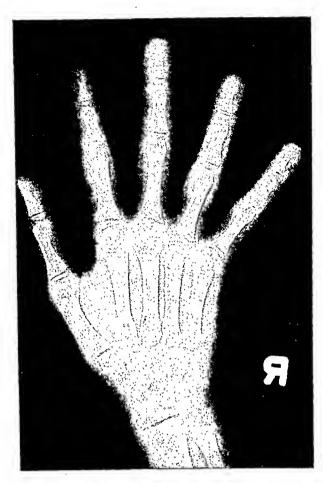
Case 1. Roentgenogram of the right hand. There is demineralization of all the bones with elongation of the metacarpal bones and the phalanges of the digits.
